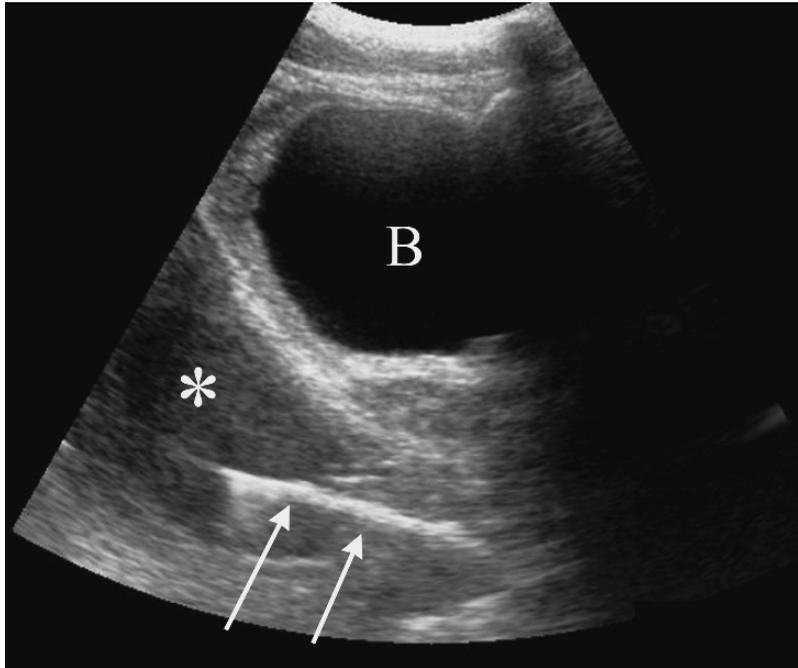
Pelvic abscess (*) is seen behind the bladder (B). The drain (arrows) is advanced with ultrasound guidance into the abscess.
